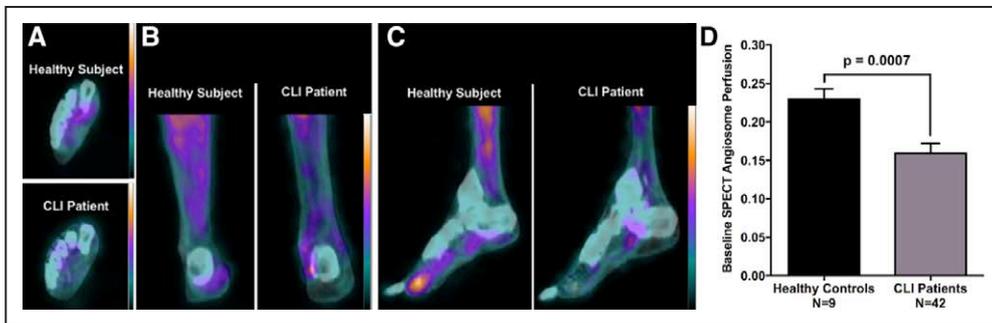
Comparison of resting single photon emission computed tomography (SPECT)/computed tomography (CT) perfusion imaging in healthy and critical limb ischemia (CLI) subjects.
